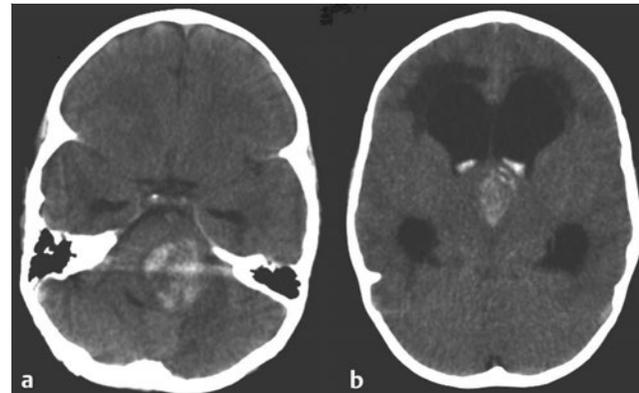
Hematomas within tumors. (a) Computed tomographic (CT) scan of a 3-year-old boy with a spontaneous bleed in a posterior fossa ependymoma. (b) CT of the head of a 5-year old girl showing a bleed within a hypothalamic astrocytoma, with resultant intraventricular hemorrhage and hydrocephalus.
